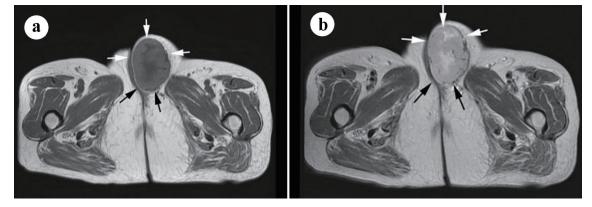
(a) Axial T1-weighted magnetic resonance imaging (MRI) of the tumor in the left labia majora revealed marginally higher signal intensity in the peripheral region and partially intermediate signal intensity in the central region than that in the surrounding muscle (arrows). (b) T2-weighted image revealed high signal intensity in the peripheral region and marked high signal intensity in the central region (arrows).
